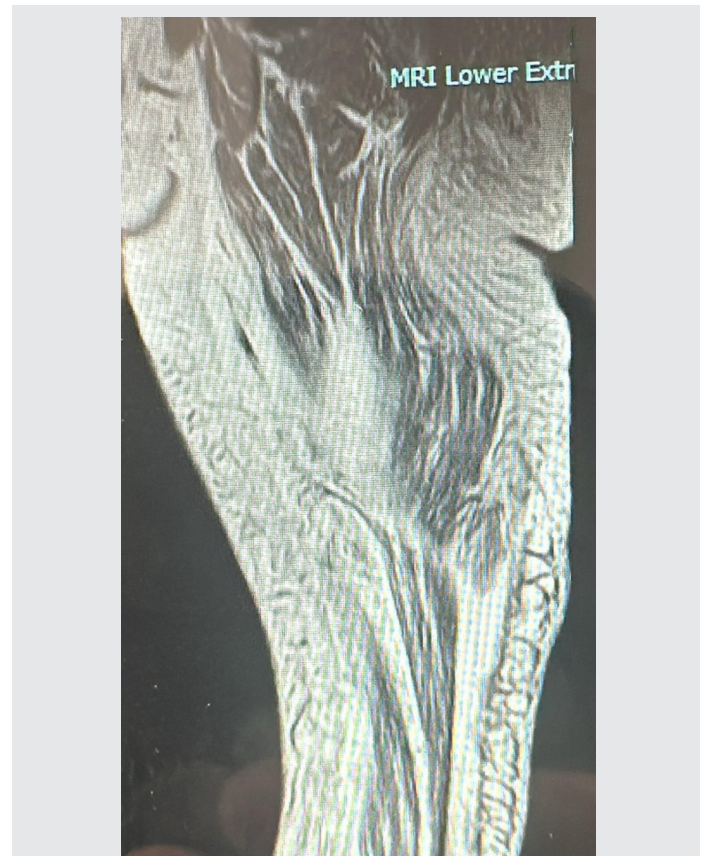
MRI of Lower Extremity.
